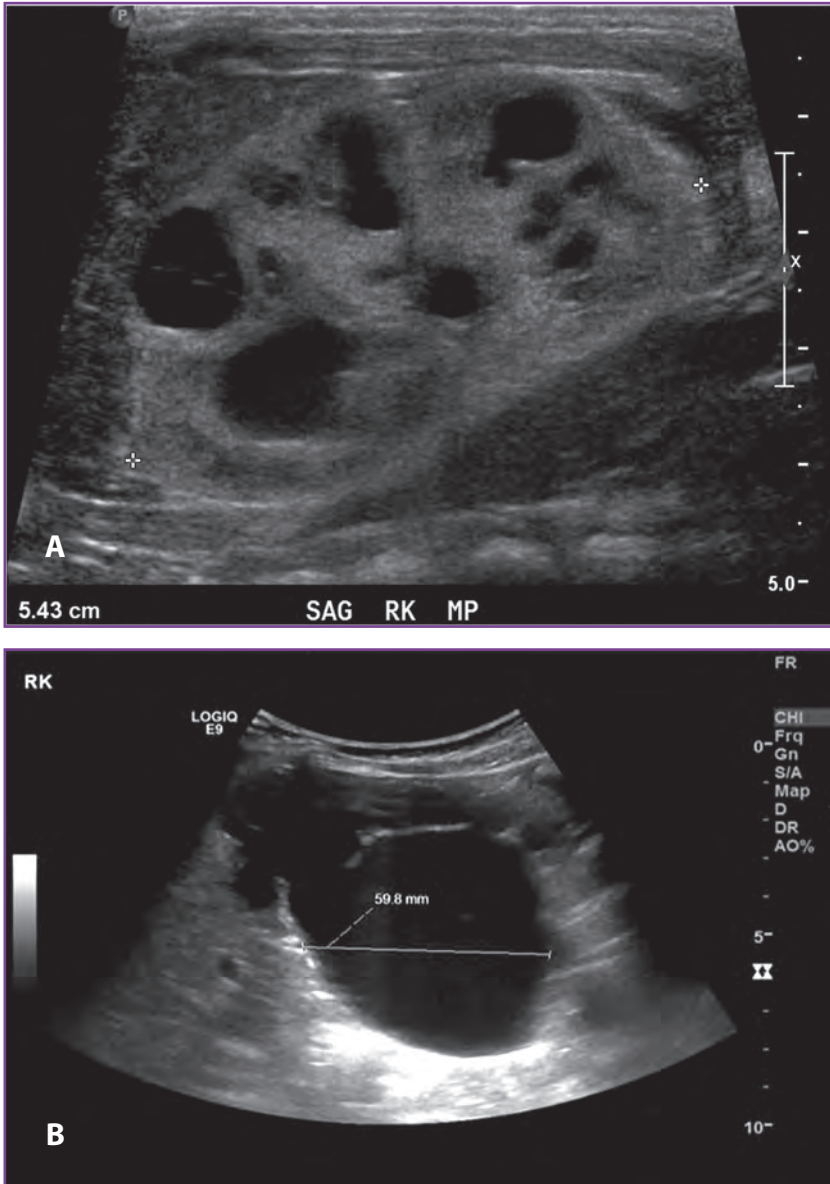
A, Prenatal ultrasonography (US) demonstrates hydronephrosis (dilated renal pelvis and calyces). B, Postnatal US demonstrates hydronephrosis with both renal pelvis and calyceal dilatation, as well as cortical thinning.
